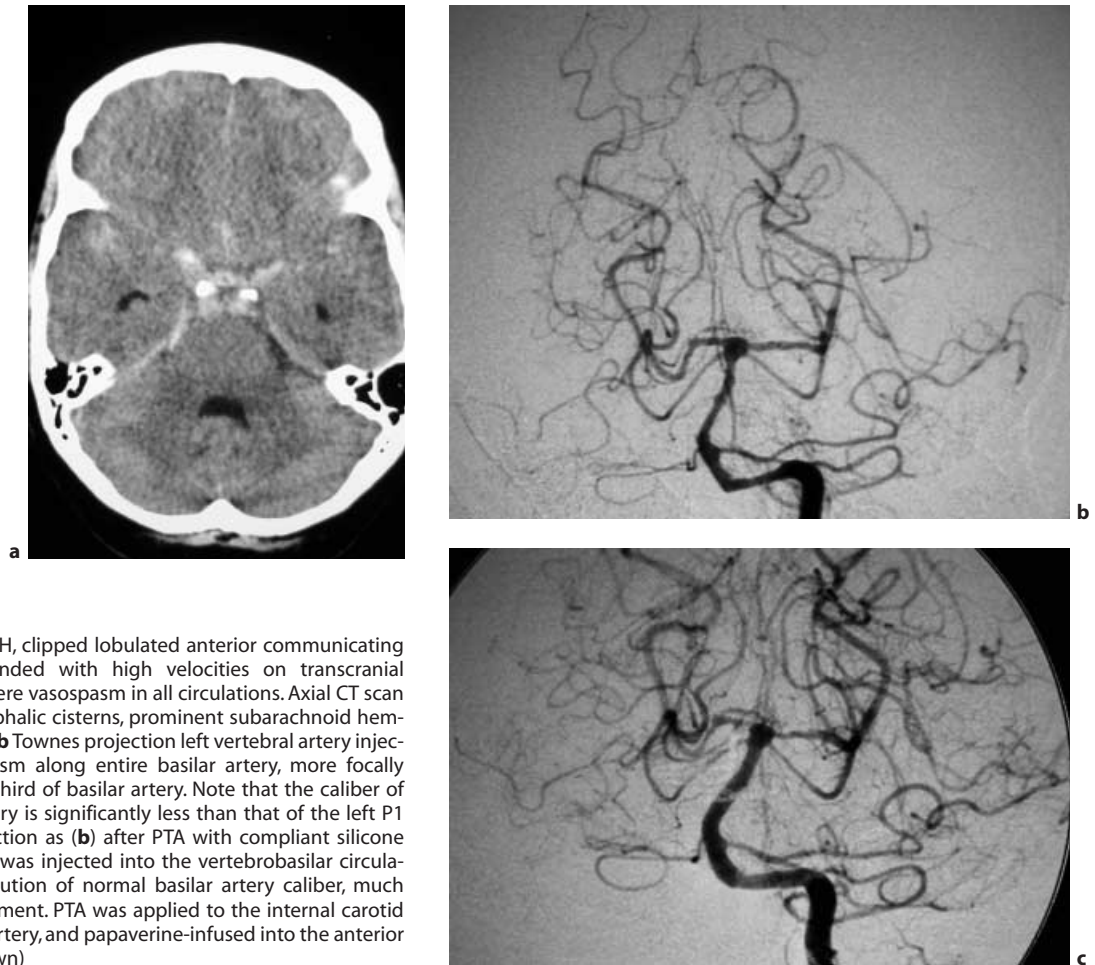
a Day 7 after SAH, clipped lobulated anterior communicating artery aneurysm, obtunded with high velocities on transcranial Doppler ultrasound, severe vasospasm in all circulations. Axial CT scan at level of perimesencephalic cisterns, prominent subarachnoid hemorrhage, Fisher grade III. b Townes projection left vertebral artery injection. Moderate vasospasm along entire basilar artery, more focally severe at terminal one-third of basilar artery. Note that the caliber of the terminal basilar artery is significantly less than that of the left P1 segment. c Same projection as (b) after PTA with compliant silicone balloon. No papaverine was injected into the vertebrobasilar circulation. Note the reconstitution of normal basilar artery caliber, much greater than the P1 segment. PTA was applied to the internal carotid artery, middle cerebral artery, and papaverine-infused into the anterior cerebral artery (not shown)
